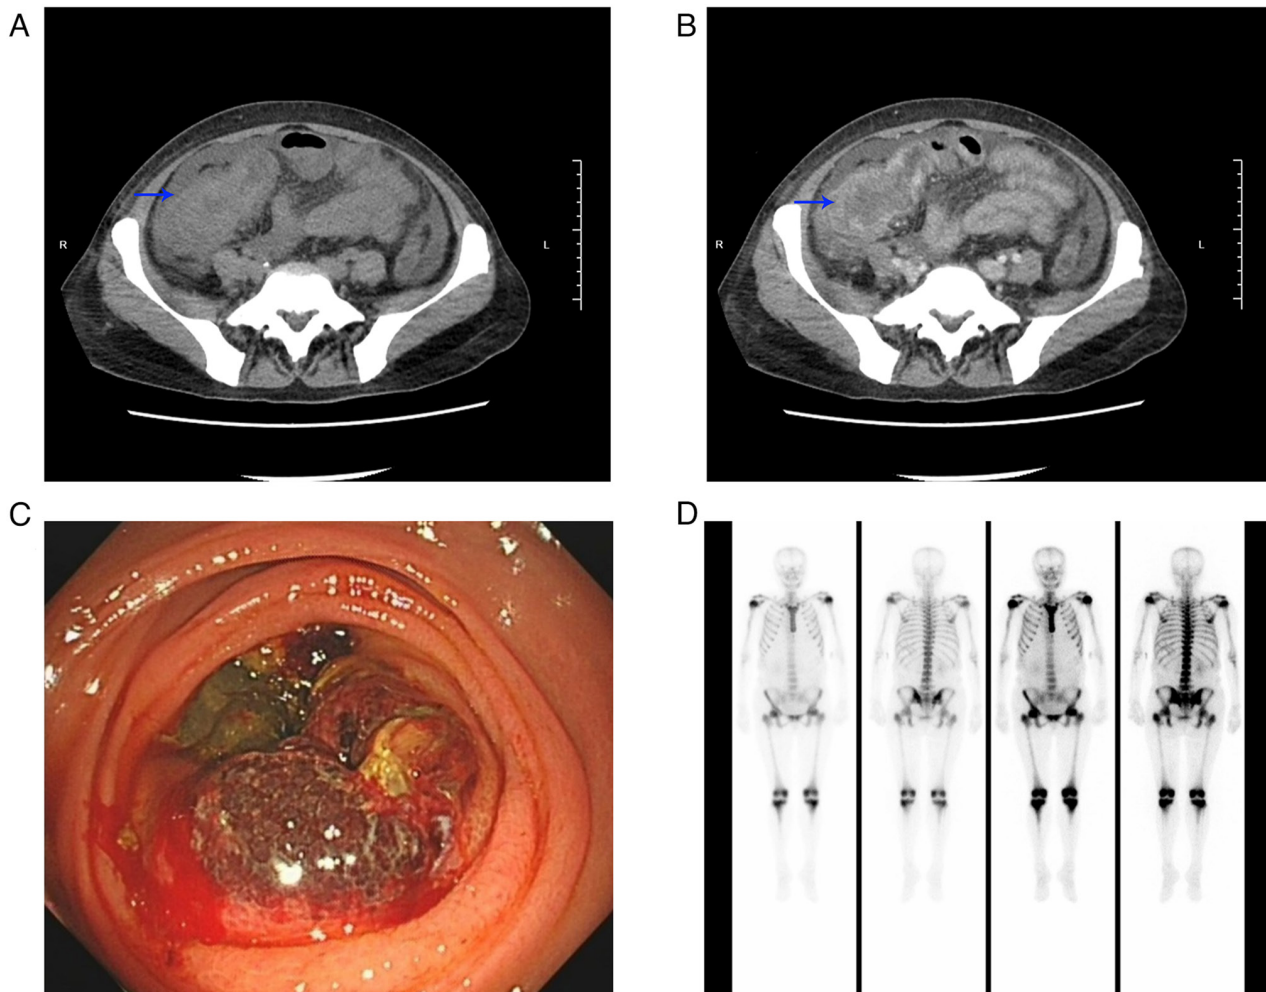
Preoperative examination of the patient with a sclerosing extramedullary hematopoietic tumor. (A) Thickened cecal wall and turbid surrounding mesentery shown by abdominal computed tomography (blue arrow indicates the tumor). (B) No abnormal enhancement was observed after enhancement (blue arrow indicates the tumor). (C) A huge necrotic mass was visible in the cecum, blocking the intestinal cavity during colonoscopic examination. (D) The nuclear medical examination comprising a whole-body bone scan revealed a superscan appearance, in which the contrast in radioisotope uptake between axial bone and soft tissue was markedly enhanced.
